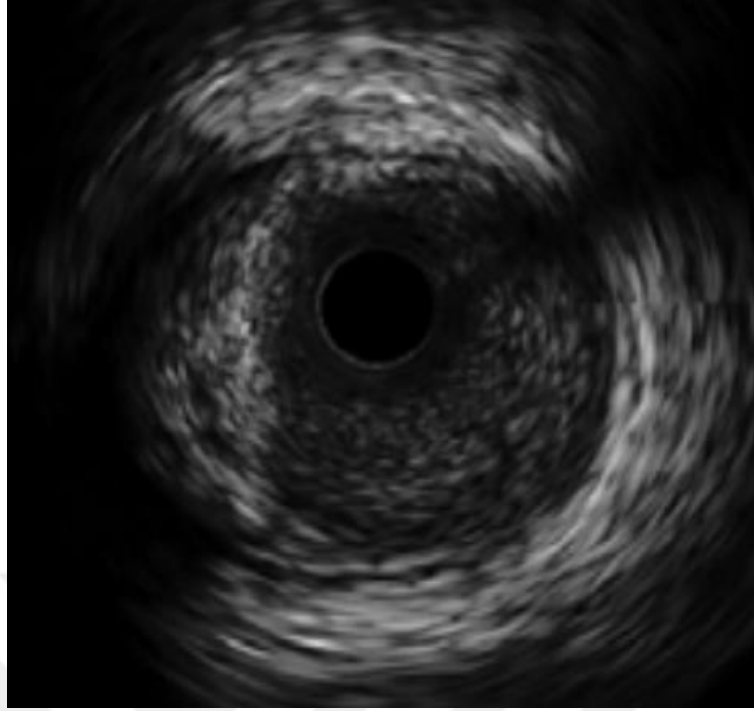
A view of coronary atherosclerosis gathered from intravascular ultrasound [44]
